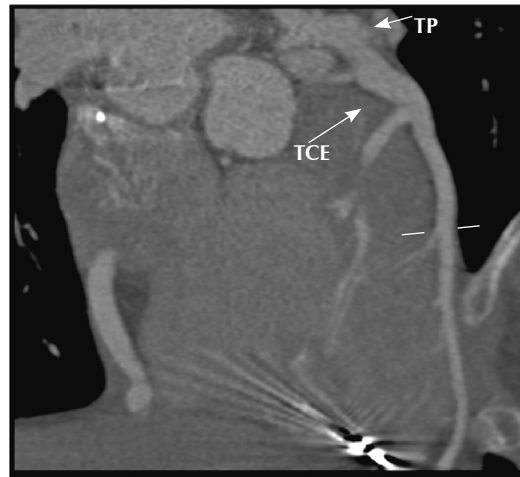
3D computed tomography angiography reconstructions showing the PT originating the LMCA.
